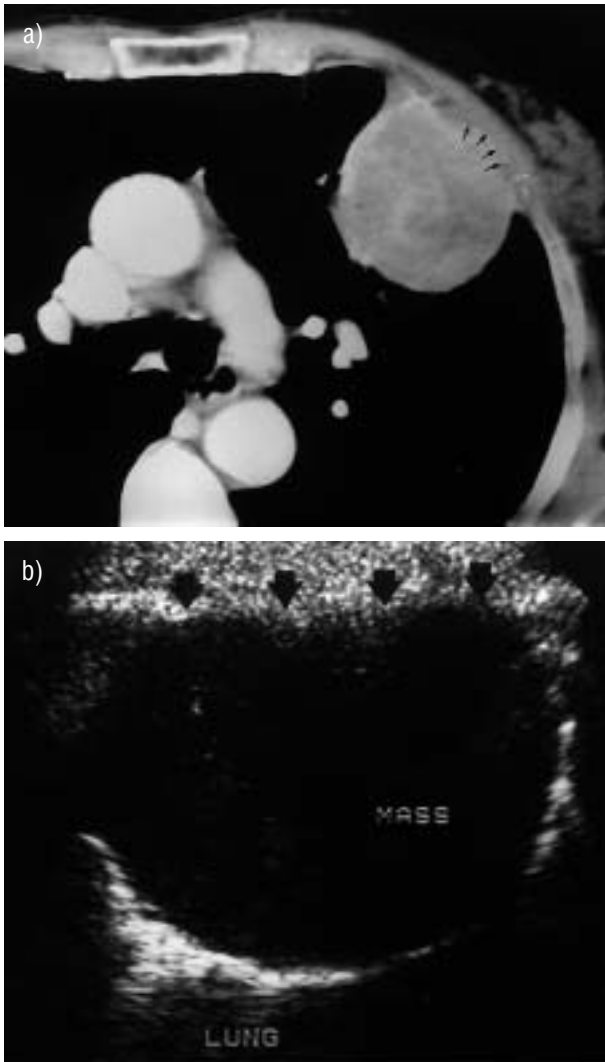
a) Computed tomography scan suggesting infiltration of pleural fat (arrows). b) Lack of movement relative to chest wall (arrows) confirms invasion.
